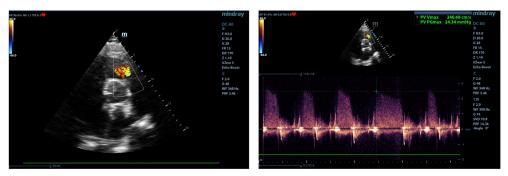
d.2. Moderate pulmonary regurgitation (left: turbulent diastolic flow; color Doppler; right: slow deceleration slope CW Doppler, both in parasternal short axis view) in a patient with severe pulmonary hypertension
